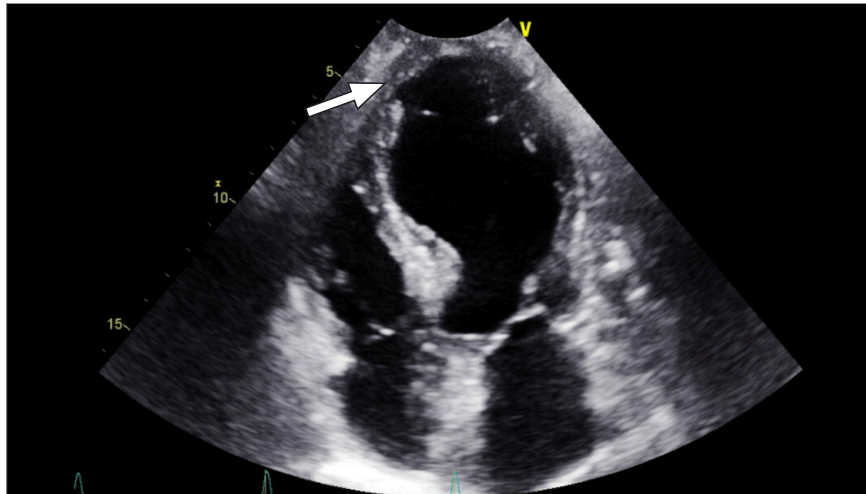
Transthoracic echocardiogram after esophagogastroduodenoscopy shows an apical 4-chamber view with an estimated left ventricular ejection fraction of 10% to 15%, moderate left ventricular dilatation with apical ballooning (arrow), and mild left atrial dilatation.
